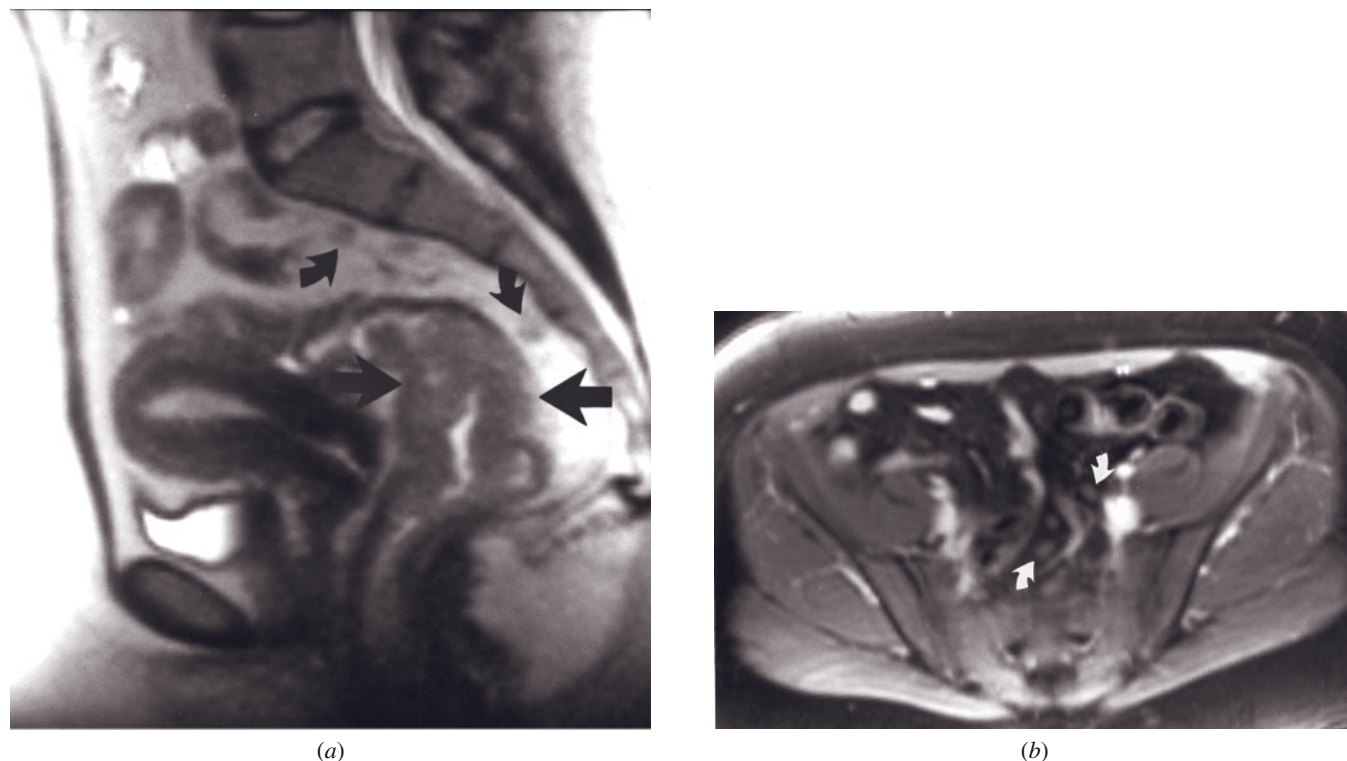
Rectosigmoid colon adenocarcinoma. Sagittal SS-ETSE (a) and 90-s postgadolinium fat-suppressed SGE (b) images. Markedly thickened tumor mass (large arrows, a) is noted in the rectosigmoid region on the SS-ETSE image. Multiple regional lymph nodes less than 1 cm in diameter are well demonstrated in the pelvis (curved arrows, a, b). Small nodes are best shown on gadolinium-enhanced fat-suppressed SGE images. (Reprinted with permission from Chung JJ, Semelka RC, Martin DR, Marcos HB: Colon diseases: MR evaluation using combined T2-weighted single-shot echo train spin-echo and gadolinium-enhanced spoiled gradient-echo sequences. *J Magn Reson Imaging* 12: 297–305, 2000.)
